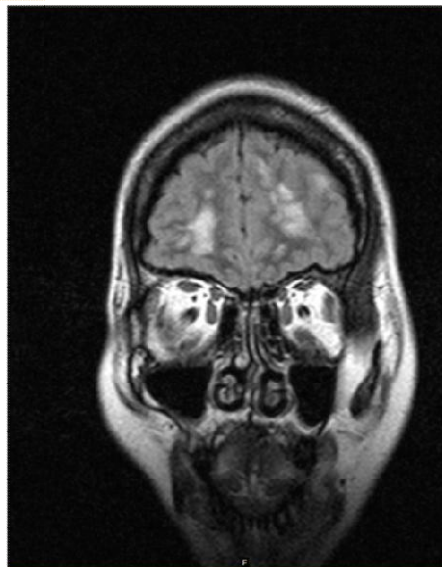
MRI Brain T2 FLAIR coronal showing subcortical white matter hyperintensities in the bilateral frontal lobes
